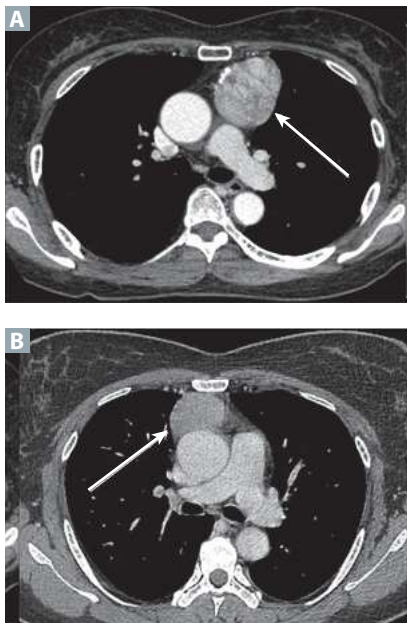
CT image of an encapsulated thymoma (arrow) in a 61-year-old female with myasthenia gravis set to undergo surgical resection. (Reproduced with permission from Lee JH, Park CM, Park SJ, et al. Value of computerized 3D shape analysis in differentiating encapsulated from invasive thymomas. *PLoS One*. 2015;10[5]:e0126175. Published 2015 May 4. doi:10.1371/journal.pone.0126175.)
